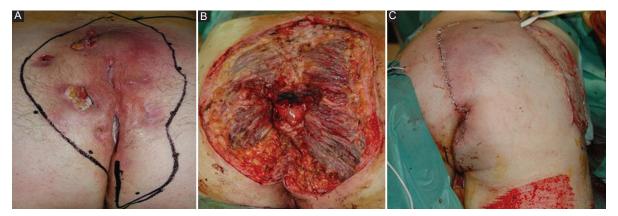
A: A 68-year-old male consulted with persistent bleeding through ulcerated fistulas and induration in the sacrococcygeal area in the past 9 months. Pilonidal sinus disease was diagnosed 20 years ago, and occasional abscesses were drained throughout this period. B: moderately differentiated squamous cell carcinoma was revealed through incisional biopsy. Computed tomography study showed bilateral affectation of the inguinal lymph nodes. A complete excision of the lesion was performed including left Gluteus maximus and coccyx. C: intraoperatory biopsy showed margins free of tumor so a transposition flap was designed to cover the defect. Three months after surgery, the patient passed away presenting local recurrence and distant metastases to lung and dorsal spin.
